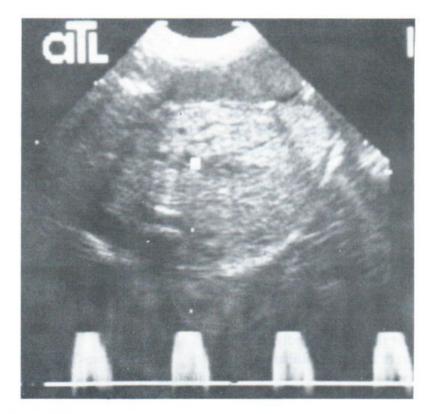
Doppler tracing from the vessel supplying the sequestration demonstrates a systemic arterial waveform.
